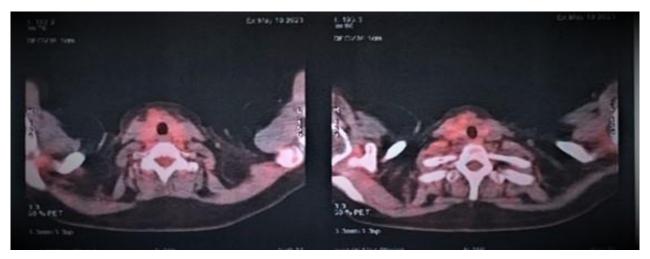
18 FDG positron emission tomography image after 6 cycles of 2nd-line chemotherapy showing the persistence of very discrete hypermetabolism in the thyroid gland.
